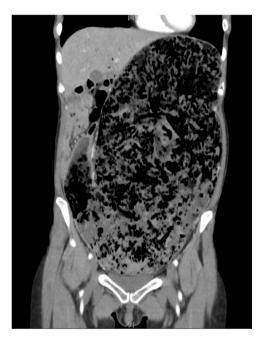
Contrast-enhanced abdominal computed tomography scan, revealing gastric dilation and portal venous gas, with no apparent gastrointestinal ischemia.
